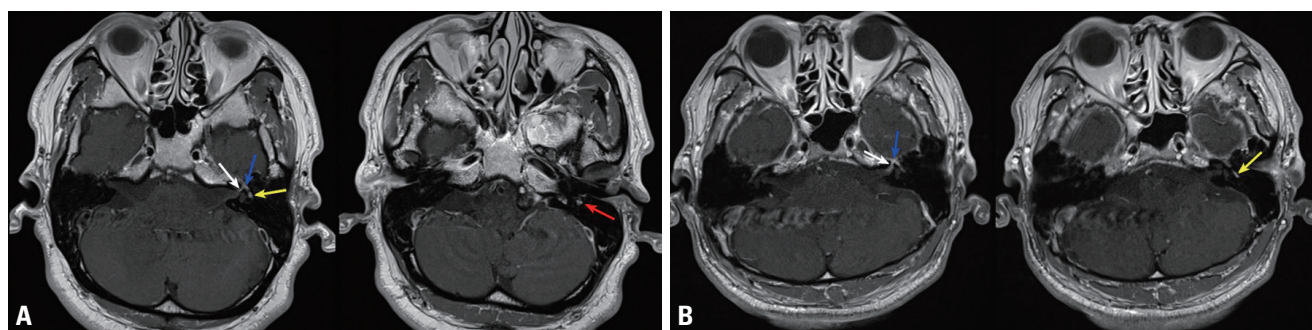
(A) Internal auditory canal magnetic resonance imaging (MRI) in case 1 (53 days after the onset): gadolinium-enhanced T1-weighted axial MRI exhibited prominent diffuse enhancement in the labyrinthine (white arrow), geniculate ganglion (blue arrow), and tympanic (yellow arrow) and mastoid segments (red arrow) of the left facial nerve. (B) Internal auditory canal MRI in case 2 (60 days after the onset): gadolinium-enhanced T1-weighted axial MRI exhibited abnormal enhancement along the labyrinthine segments (white arrow), geniculate ganglion (blue arrow), and tympanic segment (yellow arrow) of the left facial nerve.
